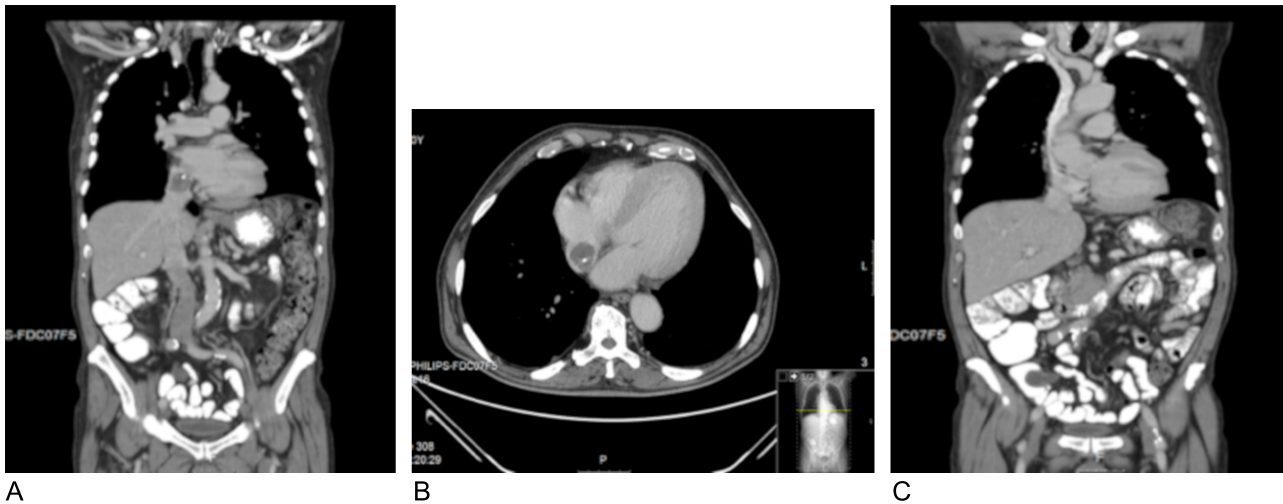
(A–C): Thoraco-abdomino-pelvic CT. Mass in the distal IVC (panels A and B) and a very enlarged mucinoid appendix (panel C).
